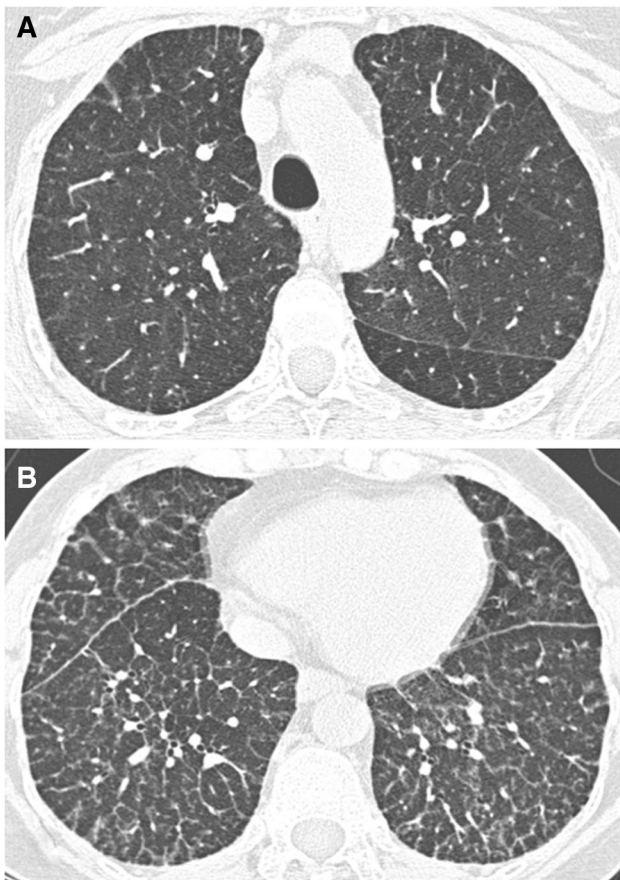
Axial CT image with lung window settings of the upper (a) and lower (b) lung zones show diffuse smooth thickening of the interlobular septa and intralobular lines, mainly in the lower lung zones
